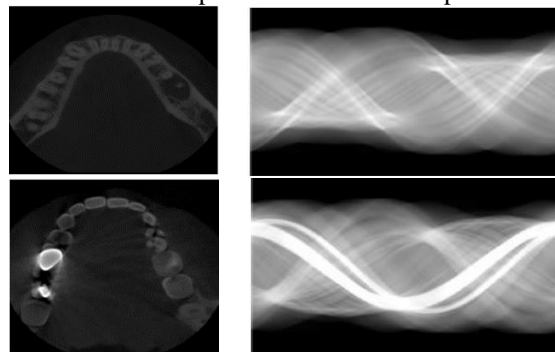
Two different slices of a dental CT. Images in the left-hand column are represented in spatial domain, while the right-hand ones are their representations in sinogram domain. Only the second slice is affected by metal artifacts.
